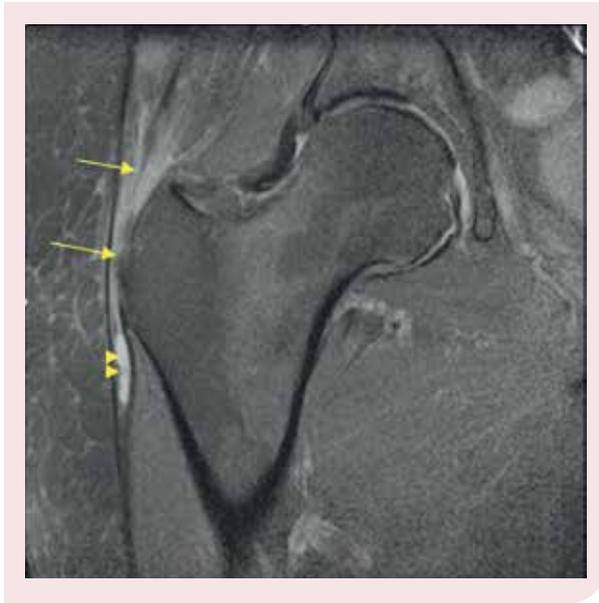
Coronal PD weighted MRI of the right hip with fat saturation demonstrating thickening and increased signal in the gluteus medius tendon at its insertion with focal discontinuity of the tendon fibres (arrows) indicative of tendinopathy and a partial thickness tear at the insertion. Bright fluid again demonstrated in the bursa (arrow heads).
